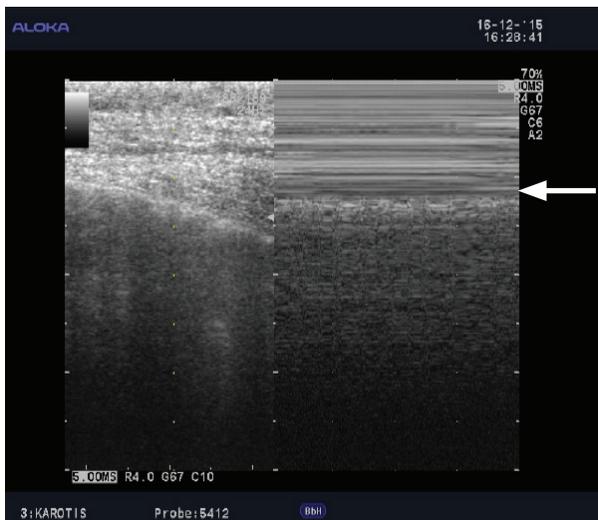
Thoracic sonography (M-mode): in the first image Seashore sign (no pneumothorax; normal finding): Above the pleura (arrow points to the pleura) air-induced reverberation artifacts are visible, below the pleura a finely granulated tissue (above waves ["sea"], below granulated ["beach"]; "seashore"; memo: "When you see the sea and the beach, you are relaxed"); in the second image stratospheric sign (pneumothorax): Here the reverberation artifacts caused by air can not only be seen above, but also below the pleura. This is caused by a complete mirror artifact at the pleura which is no longer adjacent to the wall, i.e. above the pleura one sees exactly the same as below the pleura.
